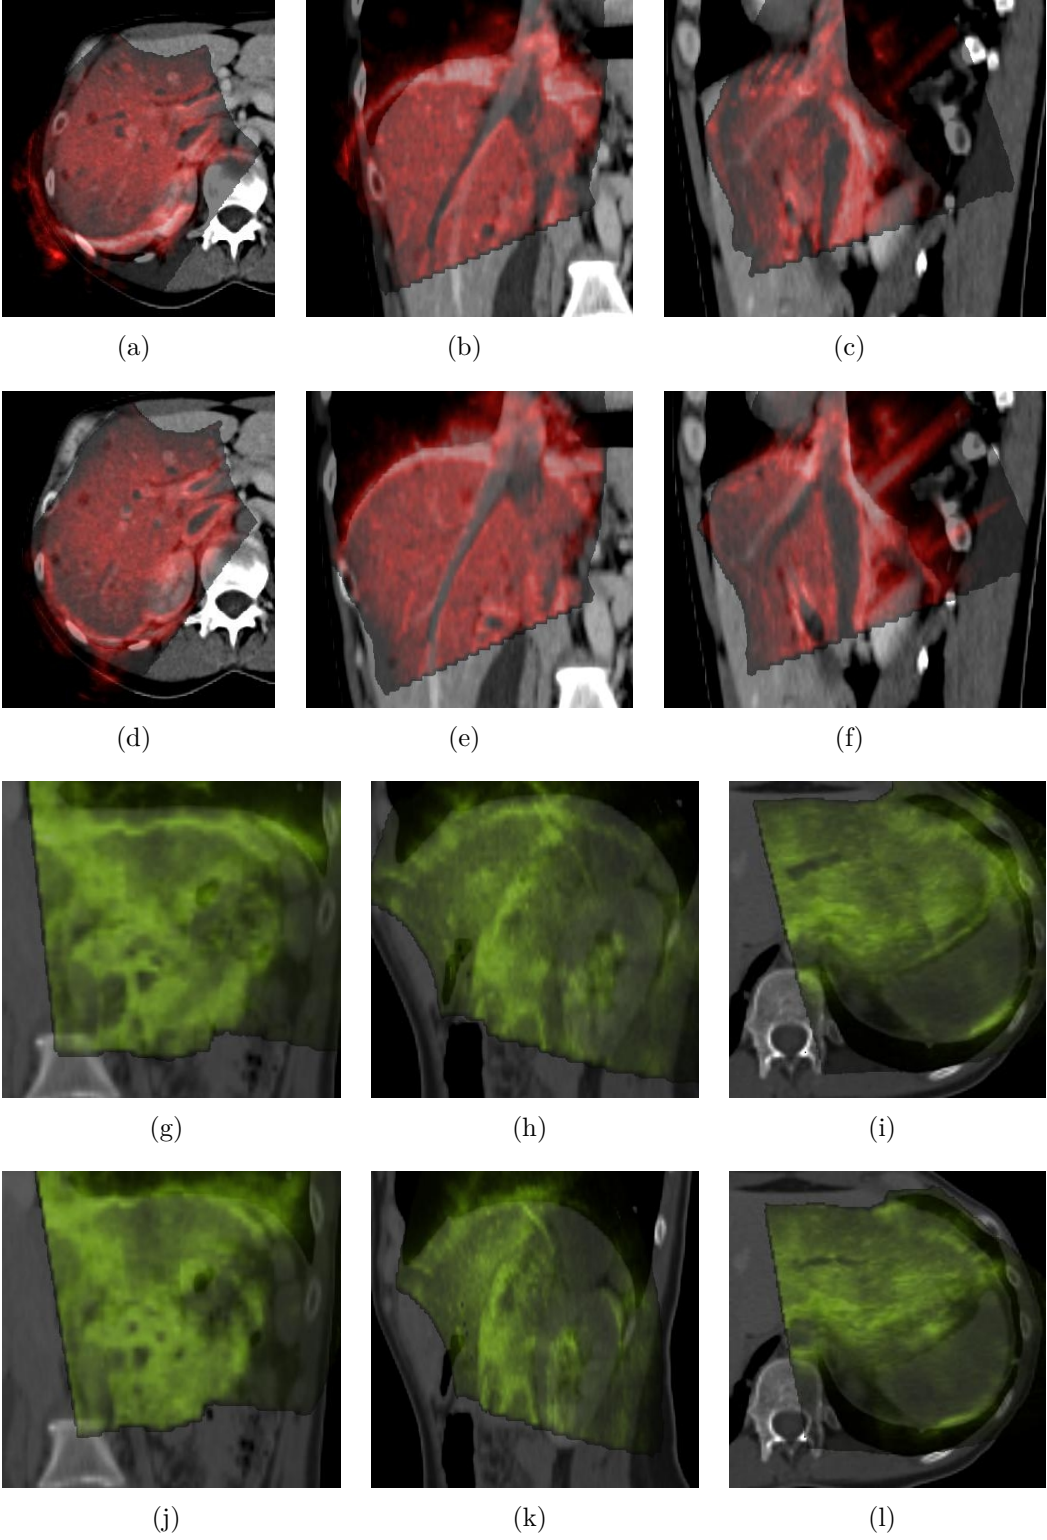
Comparison of US-CT alignment before (a-c, g-i) and after registration (d-f, j-l) for the two US volumes with small overlap depicted in figure 7.2
